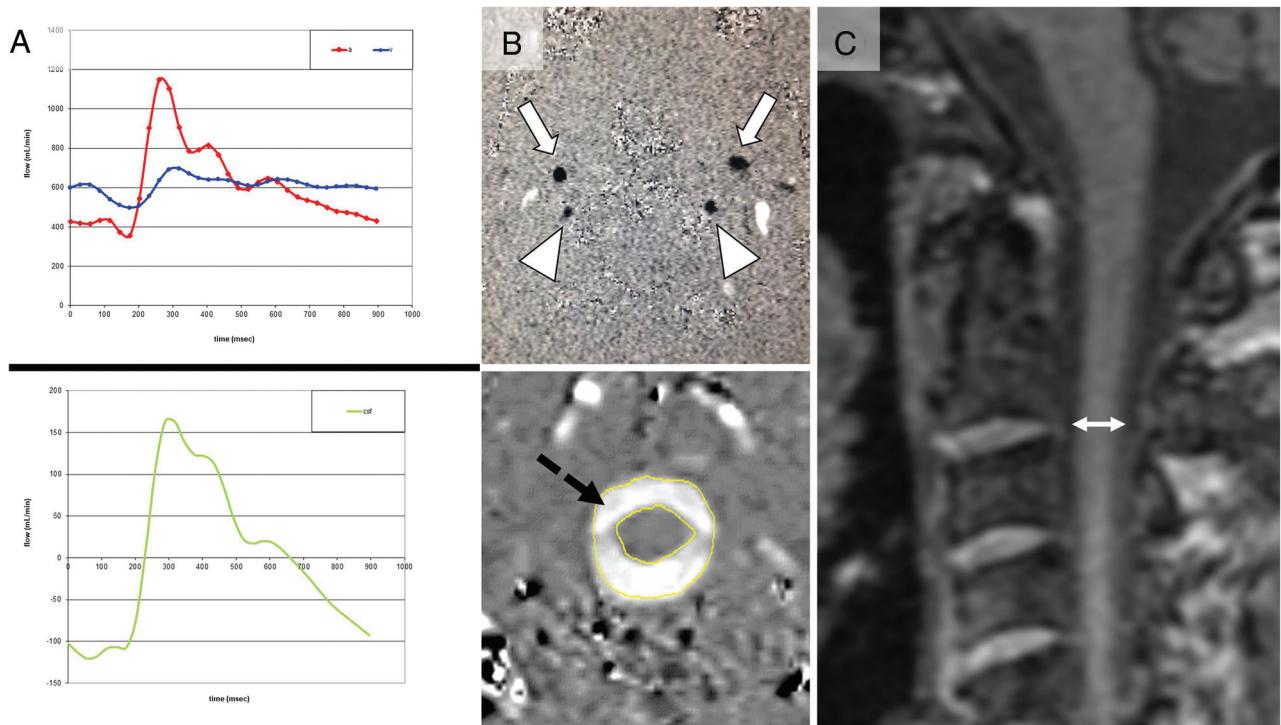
Measurement of CSF/blood flow and spinal canal width. *A*, Craniospinal blood and CSF flow (milliliter/minute) during the cardiac cycle across time (millisecond). The *upper panel* shows the blood flow. During each systole, arterial blood (red) flows into the cranium and venous blood flows in a cardiac direction; outflow is too slow to compensate the resulting increase in intracranial pressure. The *lower panel* shows the resulting fast CSF outflow (green) from the brain to the spinal CSF spaces to buffer pressure peaks. *B*, VENC phase-contrast MR images of blood and CSF. The *upper panel* demonstrates the blood flow through the internal carotid arteries (arrows) and vertebral arteries (arrowheads), and the internal jugular veins are represented by the oval white spots (not marked). The *lower panel* shows the flow of CSF (black dashed arrow) from the cranium to the spinal canal. Upward flow is black, while downward flow is white. *C*, Measurement (double-sided arrow) of the maximal diameter of the spinal canal in a midsagittal MPRAGE image at the level of the intervertebral space between the second and third upper cervical vertebrae ($\varnothing_{C2/C3}$) is shown.
